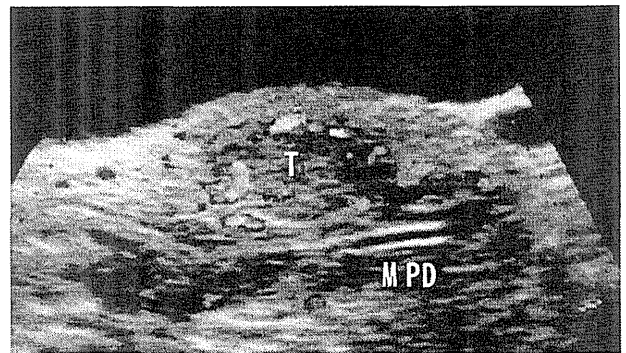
Intraoperative findings with ultrasonography.⁷² The main pancreatic duct can be clearly detected by a polyethylene stent in a tumor located very close to the main pancreatic duct (MPD), and it is easy to determine the relationship between the tumor (T) and main pancreatic duct. Geenen Pancreatic Stent, Radiopaque, 5 F, 3 cm
